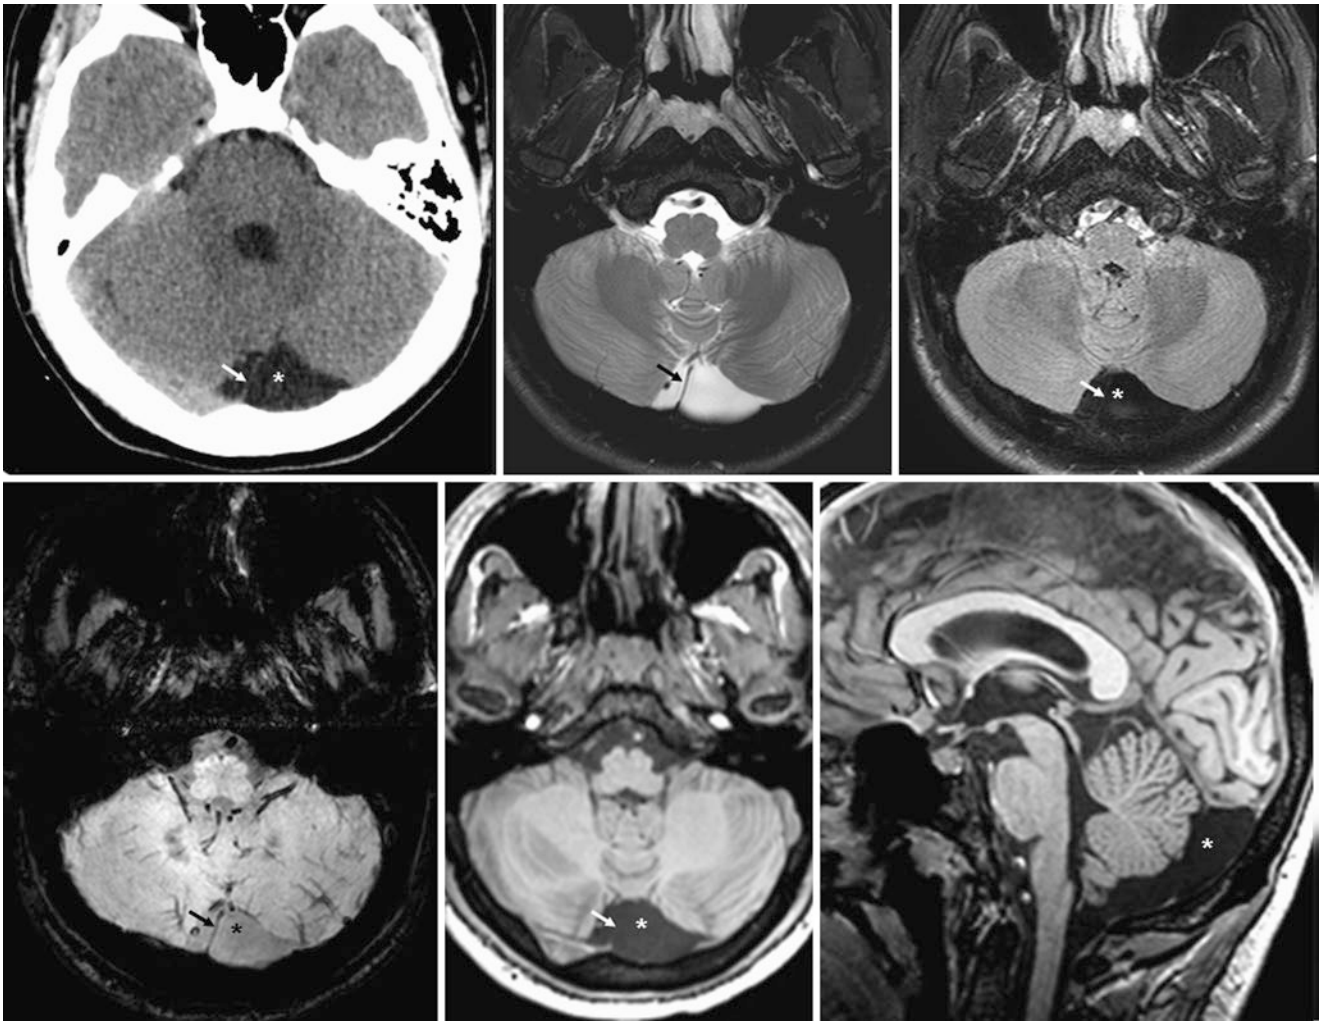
An 18 year old had a prominent retrocerebellar space (*) shown on axial NECT (*top left*), 3 T MRI T2WI (*top middle*), FLAIR (*top right*), SWI (*bottom left*), T1WI (*bottom middle*), and sagittal T1WI (*bottom right*). This cyst-like space follows the CSF on all
